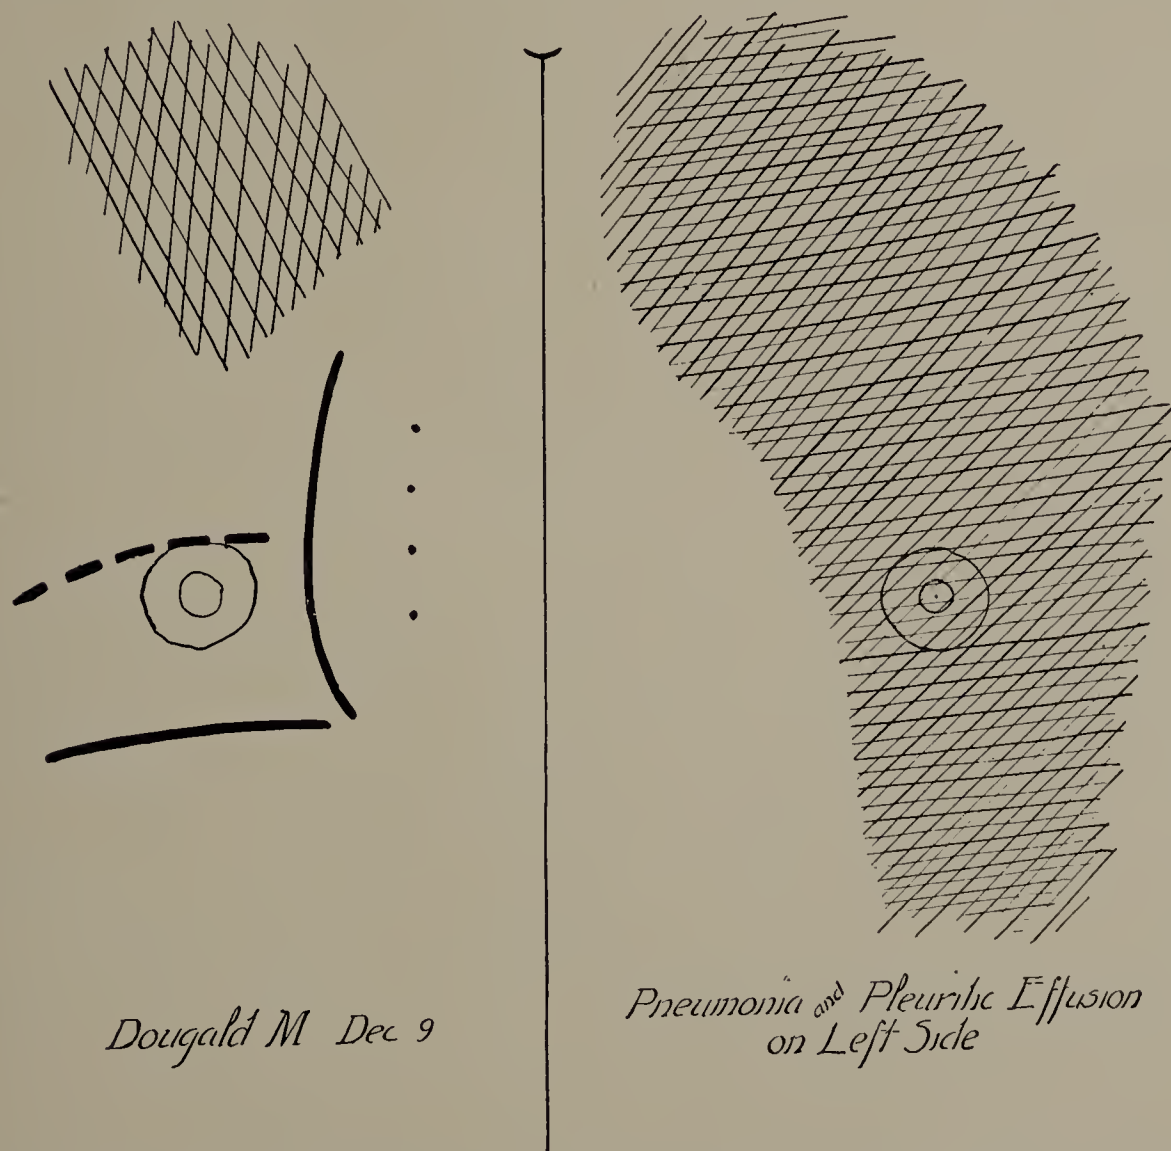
Dougald M. December 9, 1899. First X-ray tracing. Pneumonia on left side and at right apex; pleurisy with effusion on left side; heart much displaced to right. Dotted line shows right border of heart by percussion; full line, by X-rays. (Cut one-third life size.)
